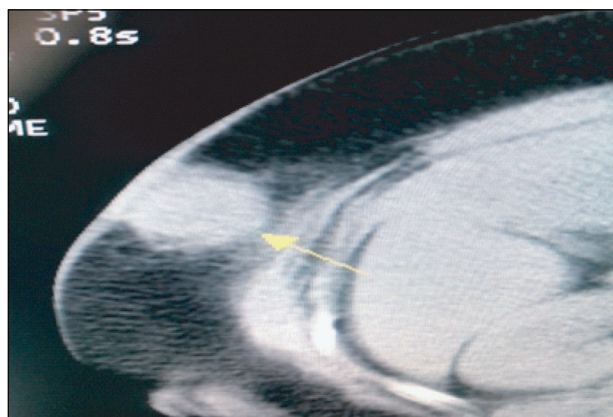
CT scan upper abdomen showing hyperdense shadow of abdominal wall mass
